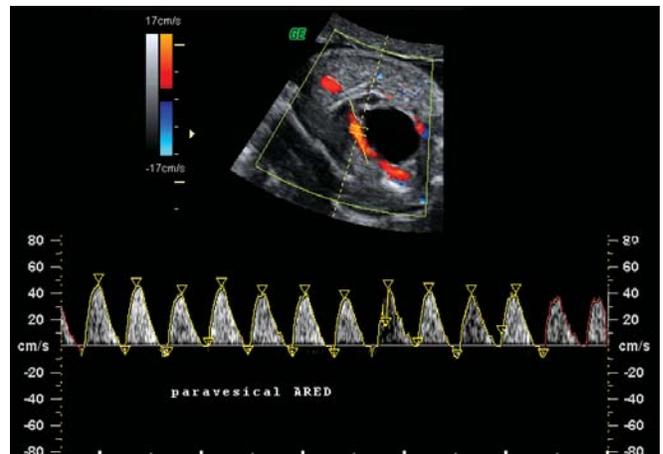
Feto-maternal Doppler with paravesical umbilical artery ARED flow in a 27 weeks fetus with severe early IUGR
